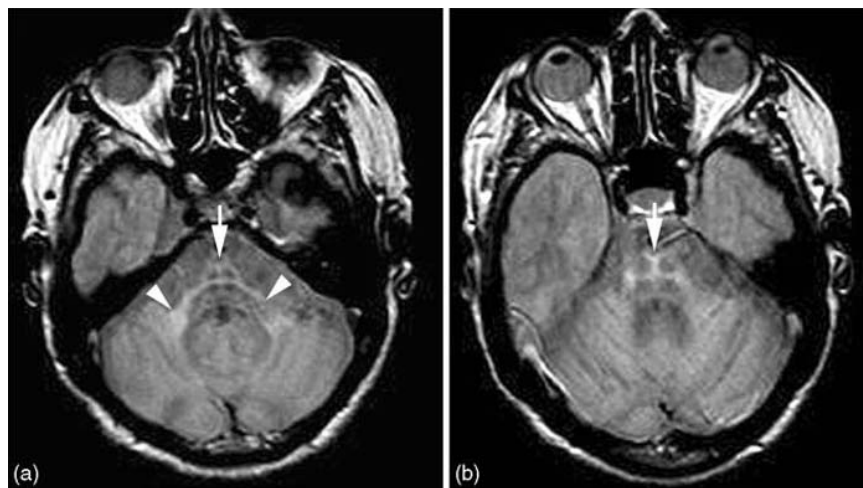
Axial proton-weighted density MRI pictures passing through lower (a) and mid pons (b) from a patient with probable MSA-C. Arrows indicate the presence of hyperintensity of pontocerebellar fibers conforming incipient (a) and fully developed (b) 'hot-cross bun' sign. Note also that signal hyperintensity involves middle peduncles extending to deep cerebellar white matter (a, arrowheads). Reproduced from Berciano et al. (2006) Olivopontocerebellar atrophy: Toward a better nosological definition. *Movement Disorders* 21: 1607–1613.
